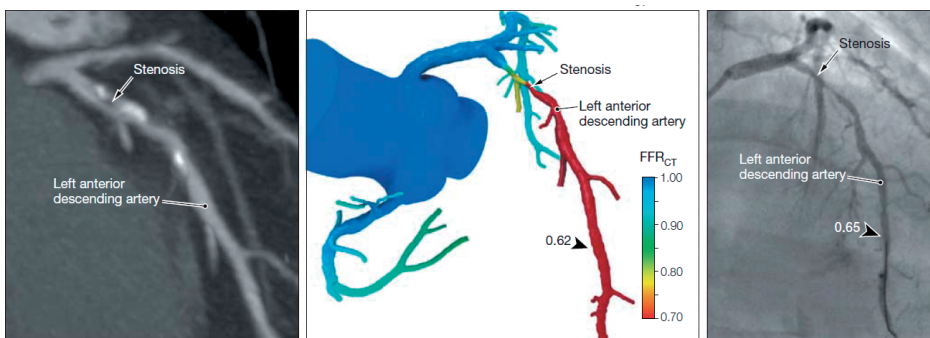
Case example of FFR_{CT} with corresponding invasive coronary angiogram.
